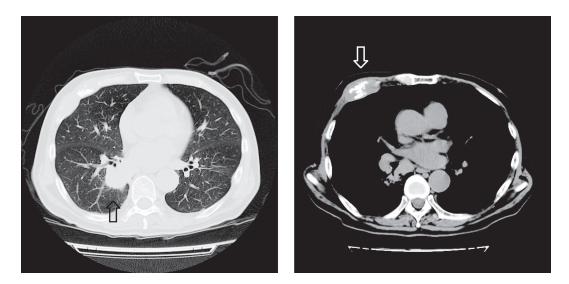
Initial computed tomography of the chest. A tumor measuring  $4\times 2$  cm was observed at the base of the right lung (left arrow). A metastatic tumor to the ribs (right arrow).
